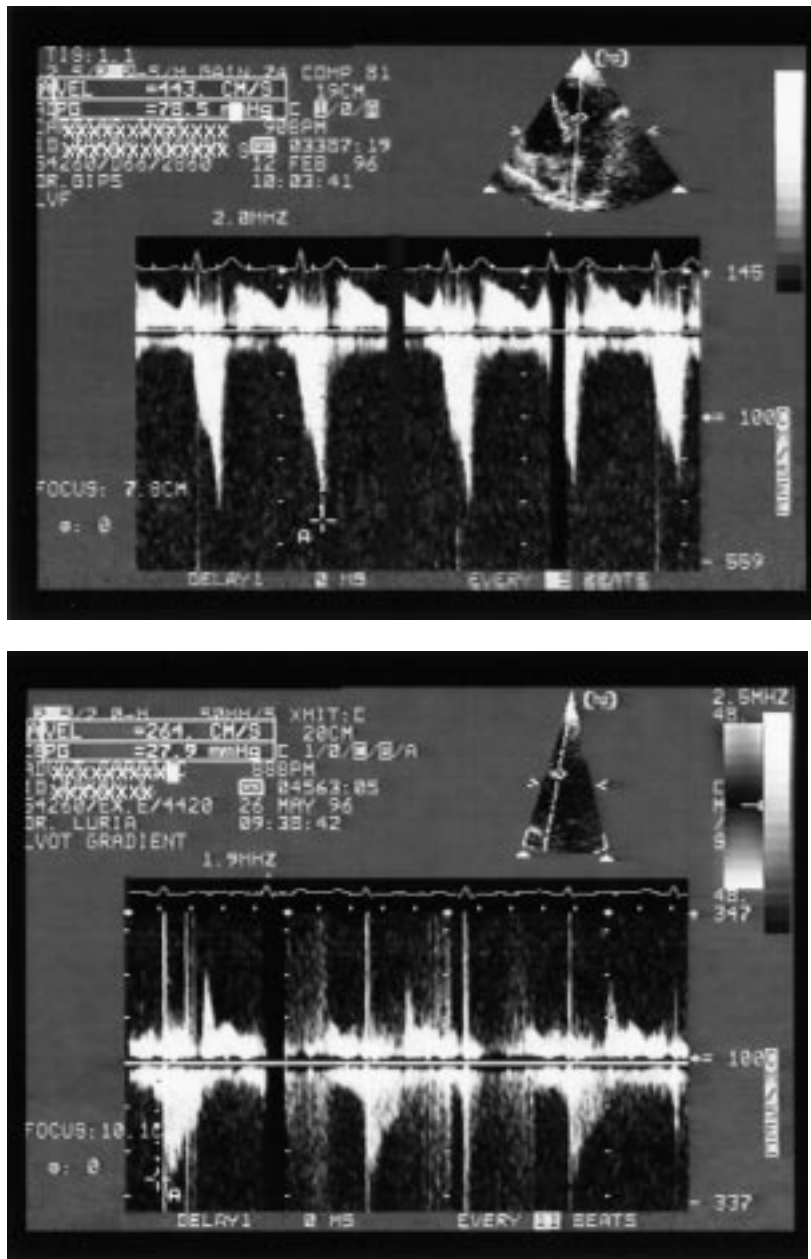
Upper tracing: continuous wave Doppler velocity at the peak of dobutamine infusion showing a left ventricular outflow gradient of 78.5 mmHg. Lower tracing: recording immediately after submaximal treadmill exercise of the same patient: left ventricular outflow gradient of only 24.6 mmHg at a similar heart rate.
